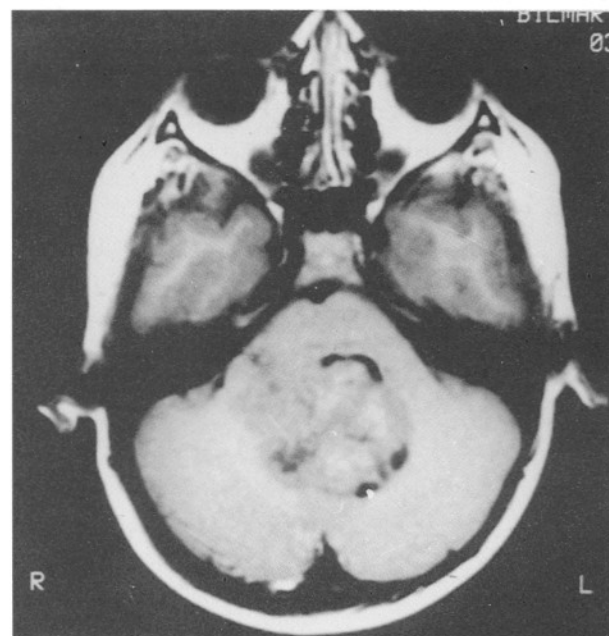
MRI showing a large midline tumour
